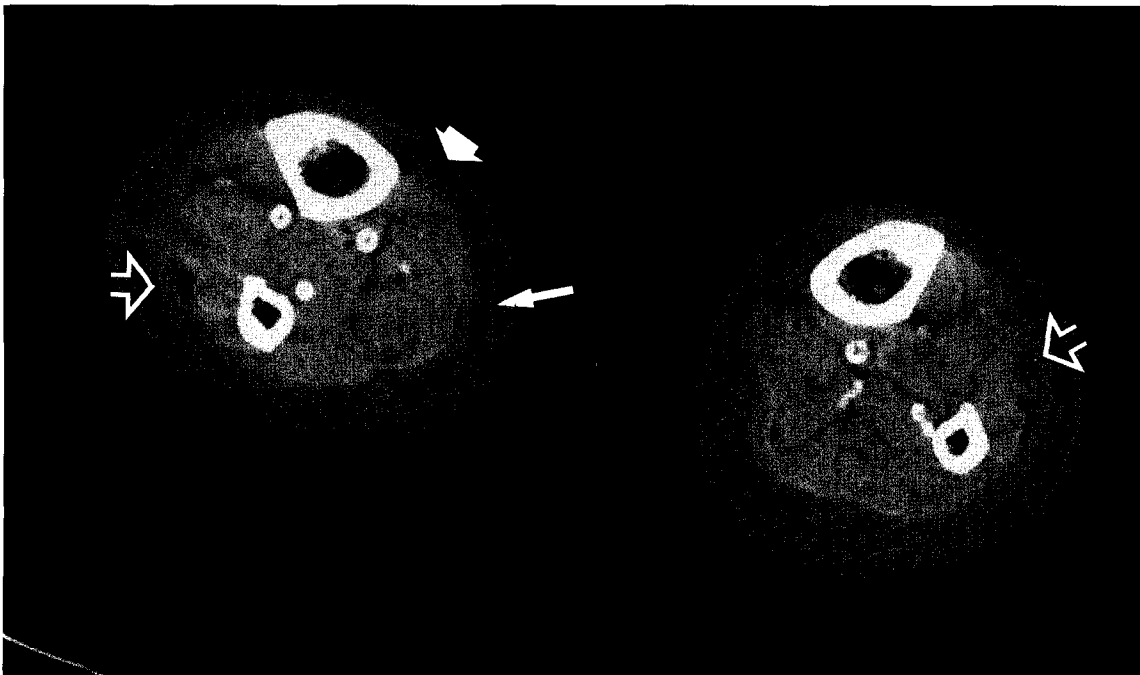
Unenhanced CT scan of bilateral lymphedema of the lower limb. Skin thickening (large solid arrow) with honeycombed pattern (small solid arrow) and collections (open arrow).
